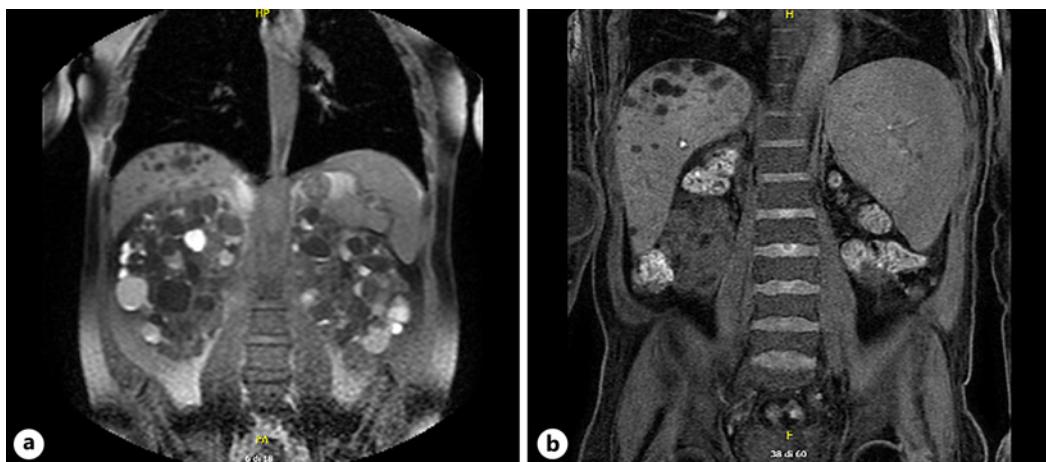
a 2014 MRI (pre-nephrectomy): multiple liver cysts (maximum diameter: 3 cm). Parenchymal renal replacement by multiple cysts (maximum diameter: 5 cm). No spleen abnormality. b 2022 MRI (post-nephrectomy): multiple liver cysts (maximum diameter: 3 cm). Splenomegaly (bipolar diameter: 17 cm).
